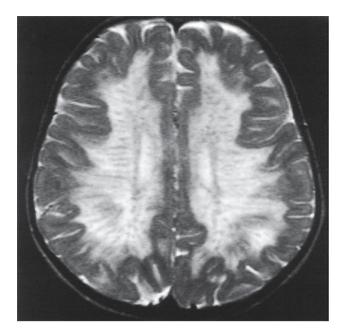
MRI of the brain of a five-year-old female with MLD. There was diffuse high T_2 signal throughout the white matter in a sunray appearance. She had regressed developmentally and had diminished deep tendon reflexes.
